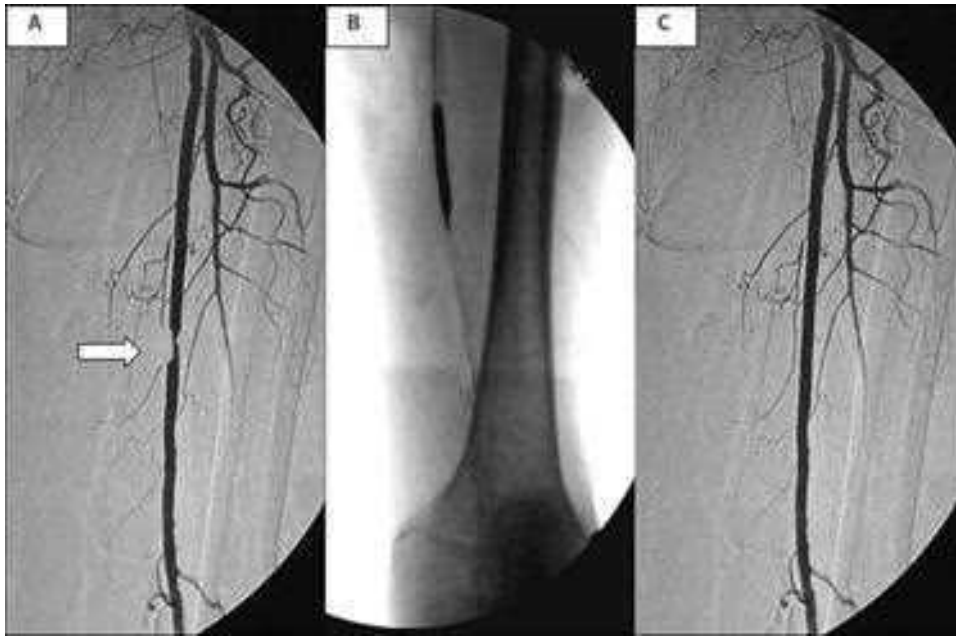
A. Angiogram demonstrating a focal stenosis in the superficial femoral artery (*arrow*). B. This lesion was treated with a balloon angioplasty catheter that inflated a dilating balloon and expanded the flow lumen. C. Completion angiogram demonstrating satisfactory radiographic result.
